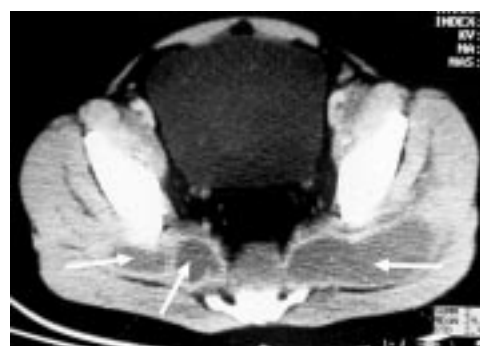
Computed tomography findings showing hypoattenuated fluid dense lesions within gluteal muscles (arrows).
